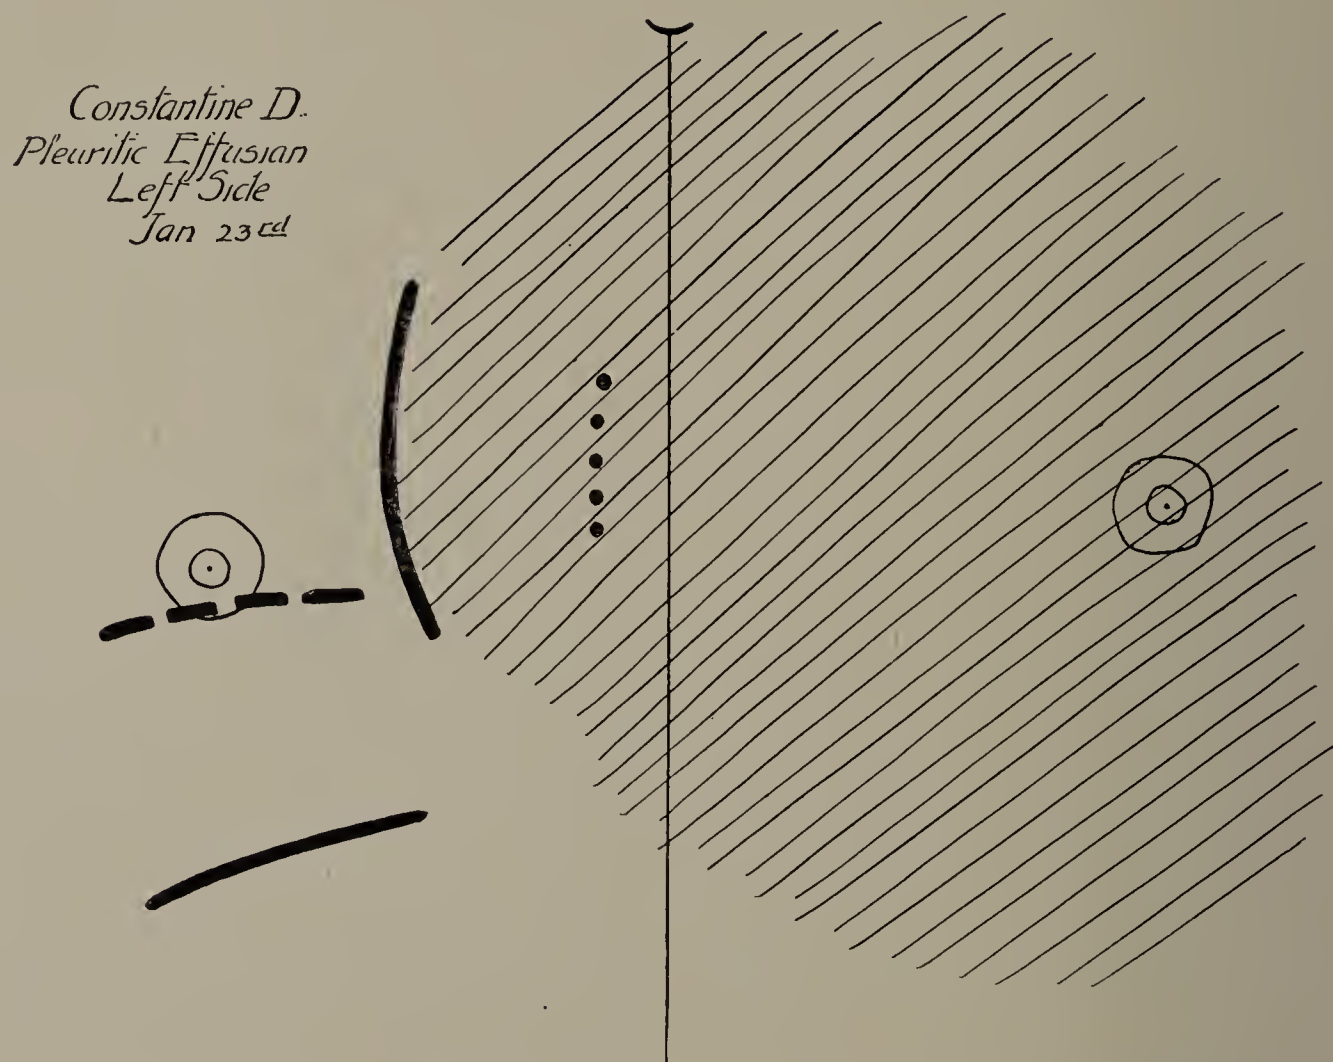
Constantine D. January 23. Cut of X-ray tracing. Pleuritic effusion on left side; heart displaced to right. Dotted line indicates position of right border as determined by percussion; full curved line to the right of it, the position of the right side of the heart as determined by the fluorescent screen. The broken and full lines below the right nipple show the position of the right half of the diaphragm in expiration and full inspiration respectively. (Cut one-third life size.)
